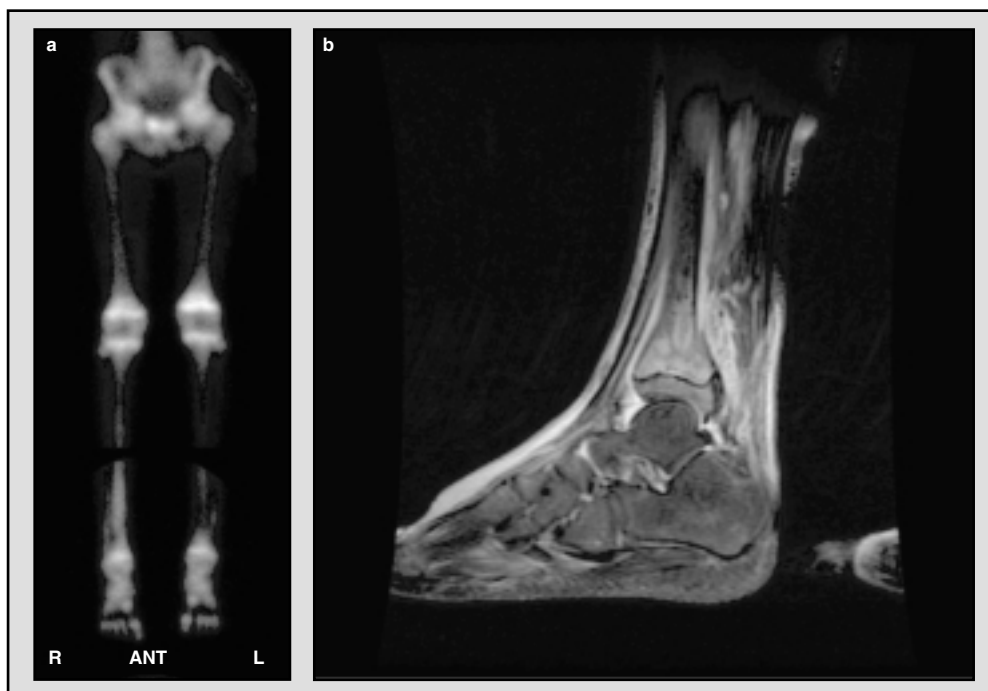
A 13-year-old boy with multifocal acute hematogenous osteomyelitis who presented with poorly localized lower limb symptoms. His bone scan on presentation was 'cold' in both distal tibias. (a) Repeat bone scan 1 week after presentation shows hot areas in the right distal tibia and left distal femur. (b) T2-weighted magnetic resonance imaging with fat suppression at the same time shows edema of the distal metaphyseal and epiphyseal regions of the right tibia, loss of bone integrity in the posterior metaphysis, and significant surrounding soft tissue edema. ANT = anterior; L = left; R = right.
